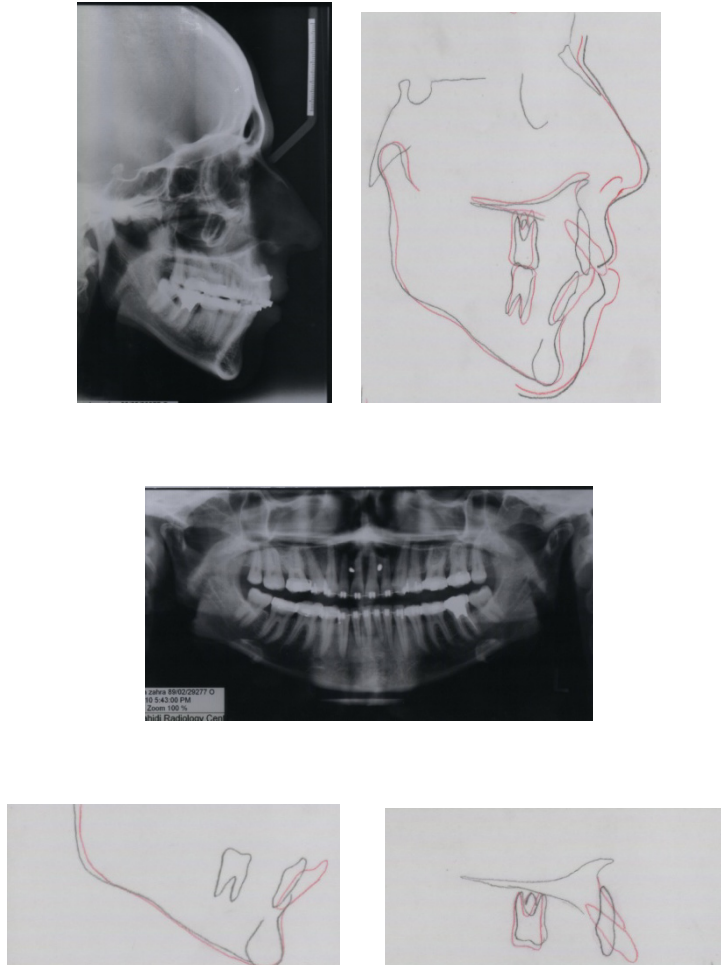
Figs 21-a to 21-e, post treatment cephalogram, superimposition of pretreatment (red) and post treatment cephalometric tracings and panoramic radiograph. Notice the miniscrews in the upper arch that are not explanted yet.
